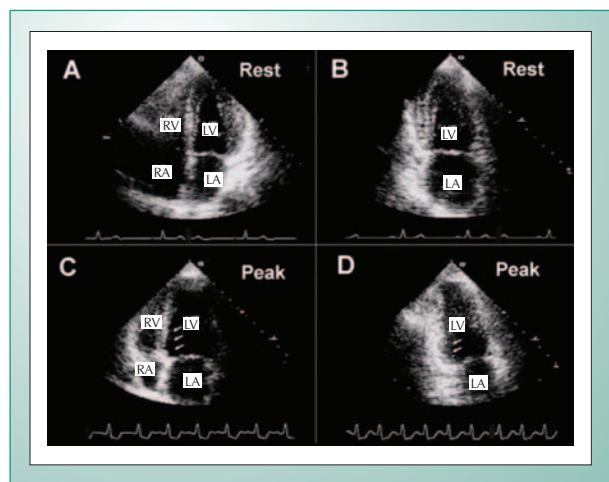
Echocardiographic images in the apical four-chamber (A) and two-chamber views (B) at rest, showing normal wall motion in all myocardial segments. At dobutamine-atropine peak stress, it was observed dyskinesia in the mid and basal segments of inferior septum (C, arrows) and akinesia of inferior wall (D, arrows).
